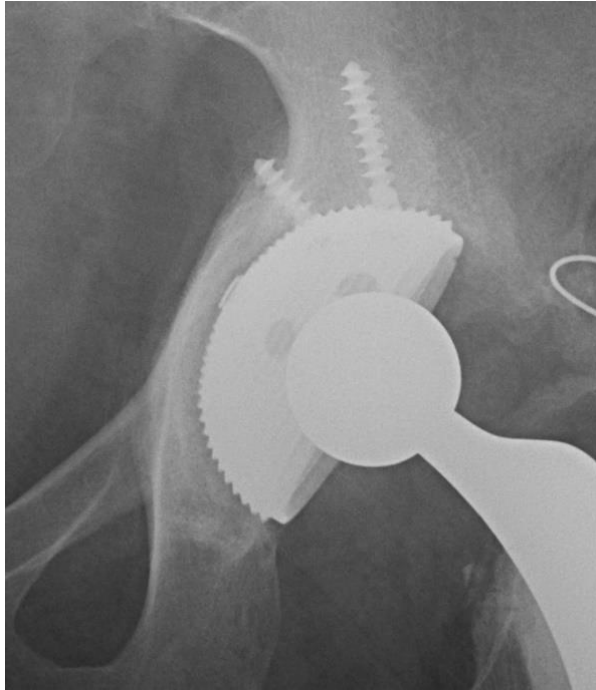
CT scan of screw fixated acetabular cup [97].
